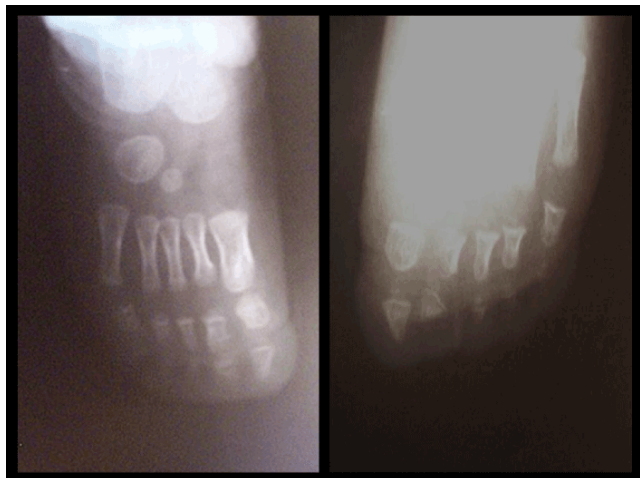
Feet x-ray images show no fusion of the bones.
